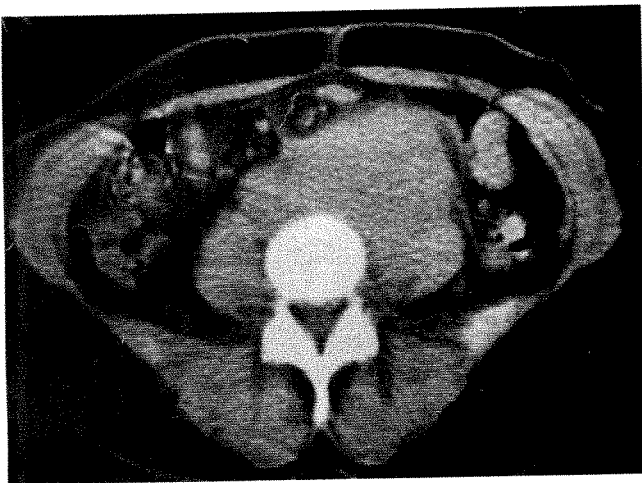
Asymptomatic 56-year-old woman treated 3 years previously for Hodgkin's disease of neck with radiation therapy; lymphangiography and laparotomy normal at that time. Questionable left-sided midabdominal mass palpable on routine examination. CT scan showing 6 cm mass within retroperitoneum, predominantly on left side, obscuring aorta, inferior vena cava, and anterior margin of left psoas muscle, consistent with recurrent Hodgkin's disease.
